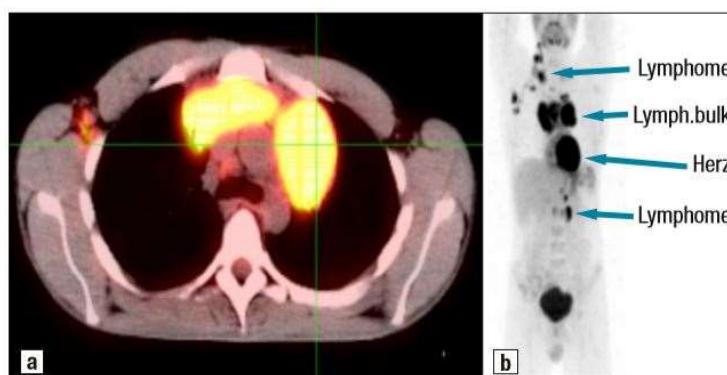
(CT), 9b (PET): Mediastinaler Lymphom-Bulk
